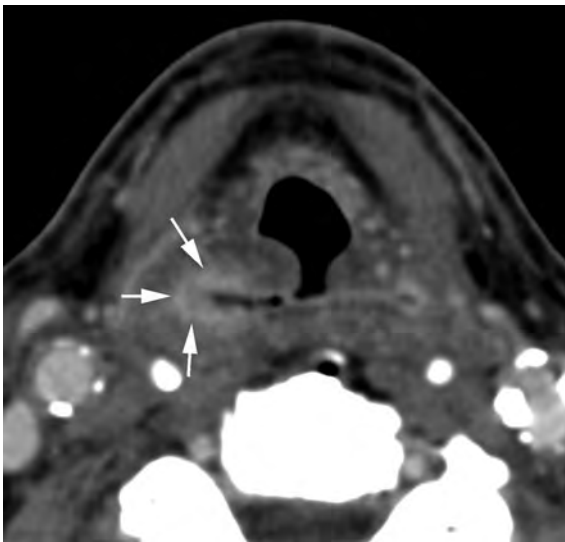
Axial contrast-enhanced CT image performed 3 months following completion of radiation therapy shows asymmetric thickening of the mucosa in the upper pyriform sinus on the right (arrows) when compared to the left that is <1 cm in thickness. Since the pyriform sinus tumor did not completely resolve, a 3- to 4-months follow-up CT study is warranted to exclude persistent tumor; this appearance can also be caused by asymmetric radiation therapy-induced mucositis or non-viable tumor. Biopsy is only recommended if there is also clinical suspicion for persistent tumor
